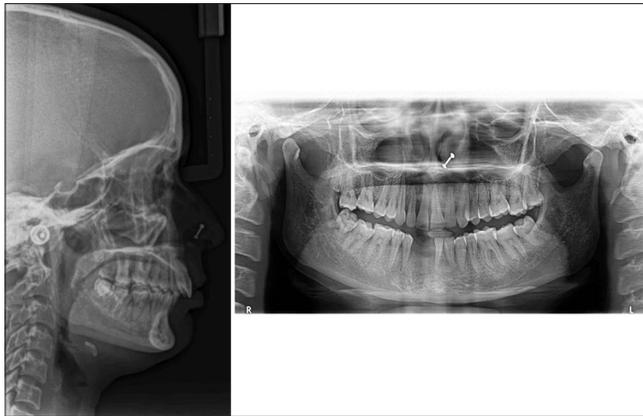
Posttreatment lateral cephalogram and orthopantomogram
